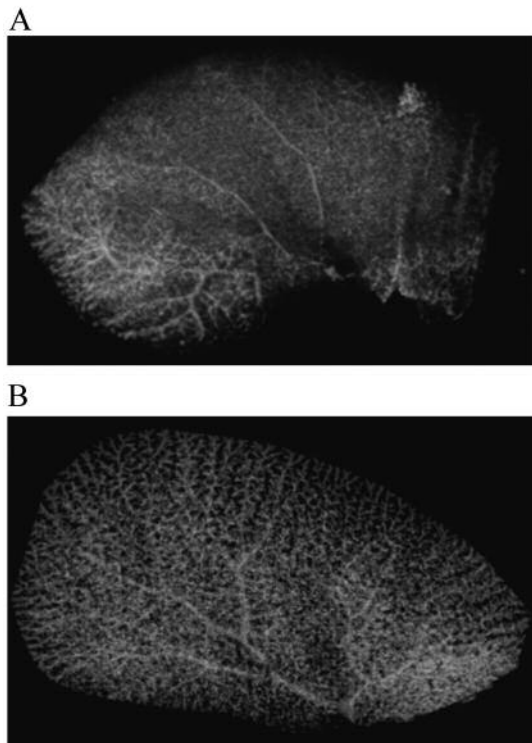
Effect of the dose of barium sulfate on angiography. Barium sulfate (A: 0.1 ml, B: 0.2 ml) was administered into the portal vein. X-ray computed tomography imaging of the liver leaf was performed.
